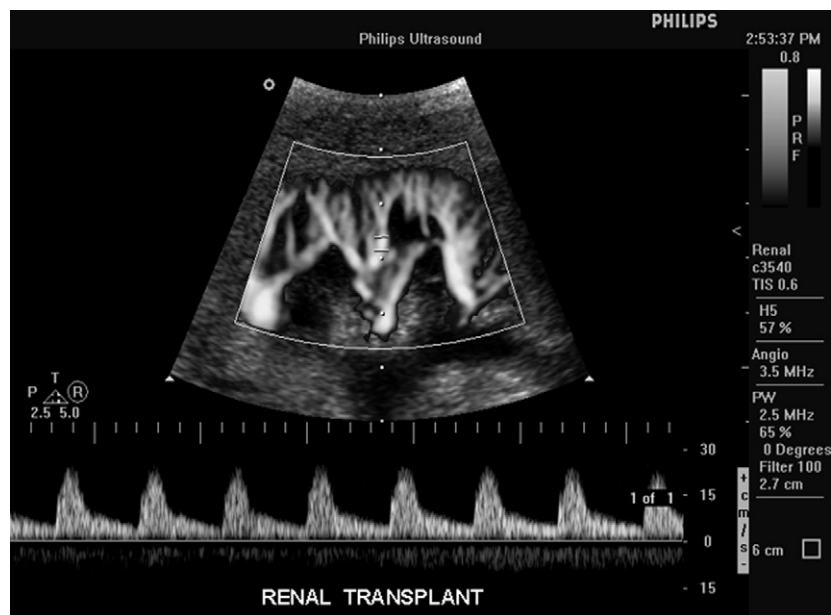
(Top) Power Doppler image of kidney with pulsed Doppler line down the center and Doppler gate in center of line. (Below) Corresponding pulsed wave Doppler spectrum. Image from a curved linear array. *Courtesy of Philips Medical Systems.*
